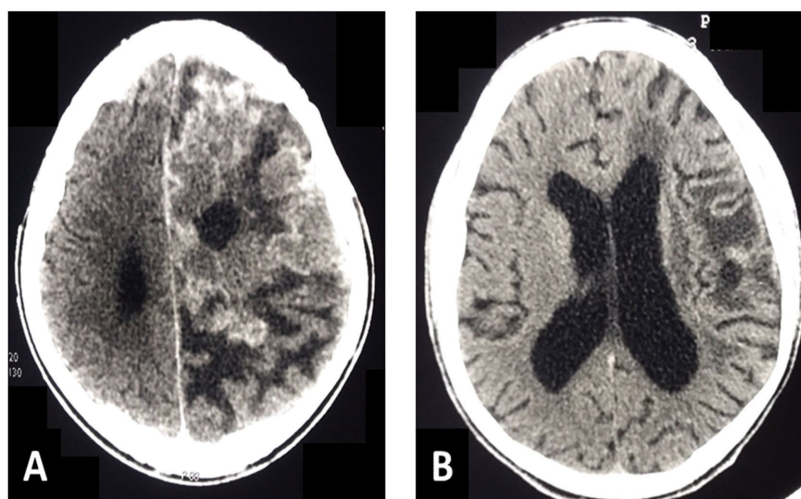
(A) Cerebral CT scan showing a heterogenous image with contrast enhancement and a digitiform edema suggesting a tumor. (B) Follow-up cerebral CT scan after one year of treatment showing residual left parietal edema.
